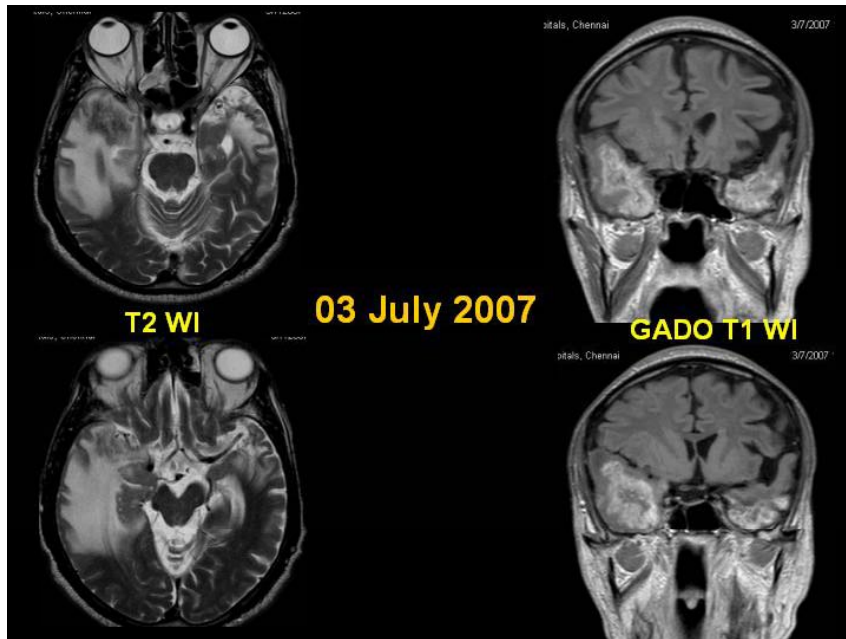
MRI after 9 months shows resolution of lesion in the left temporal lobe; lesion in the right temporal lobe appears more pronounced ; distribution of lesions consistent with radiation field
